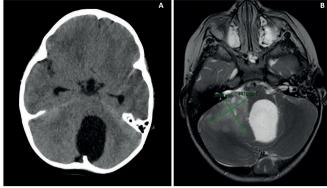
A: CT scan prior to surgery. B: NMR with contrast prior to surgery.
